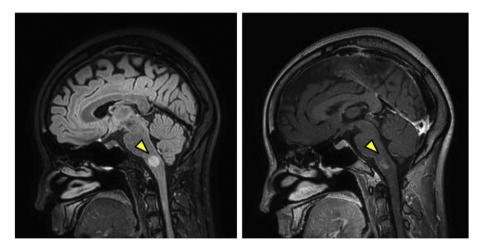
Brain MRI showed the lesion with hyperintensity on fluid-attenuated inversion recovery (left) and gadolinium enhancement (right) on day 30.
